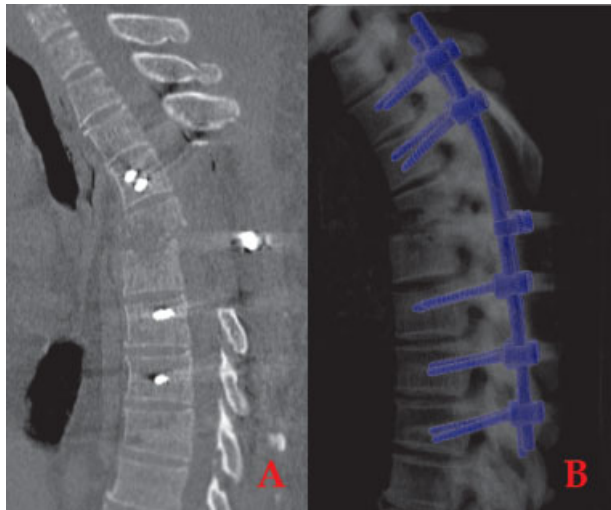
Postsurgical computed tomography scan: good decompression but not complete realignment of the vertebral bodies.
